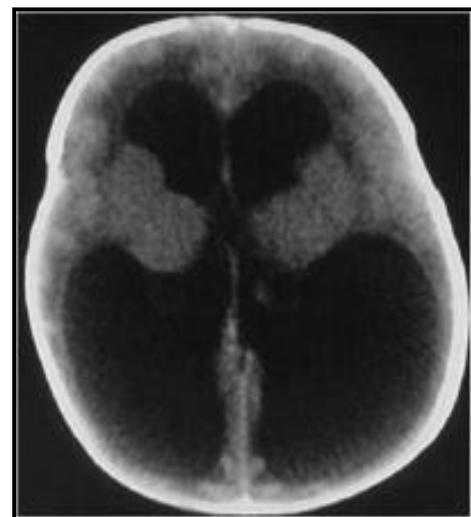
(a) CT. brain with hydrocephalus, (b) MRI Brain (T1) axial view show dilated lateral ventricles
